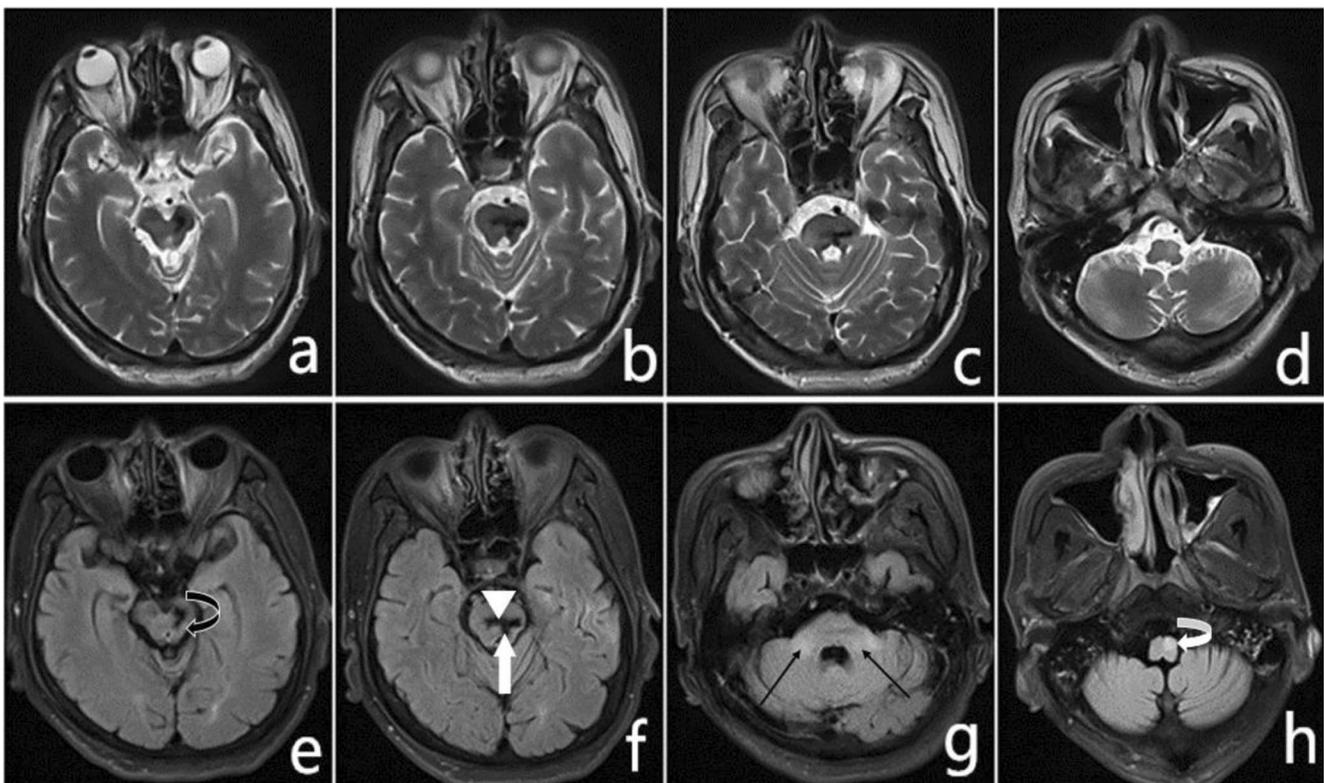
Axial T2 image (a–c) and FLAIR (e, f): Residual lesion in the midbrain (left red nucleus and substantia nigra) and pontine tegmentum, characterized by prominent hypointensity. The lesion corresponds to old hemorrhage, interrupting the red nucleus (black and curved arrow) and afferent fibers of the central tegmental tract (white arrow) located in the pons to the inferior olivary nucleus. In addition, the old lesion in the pons
